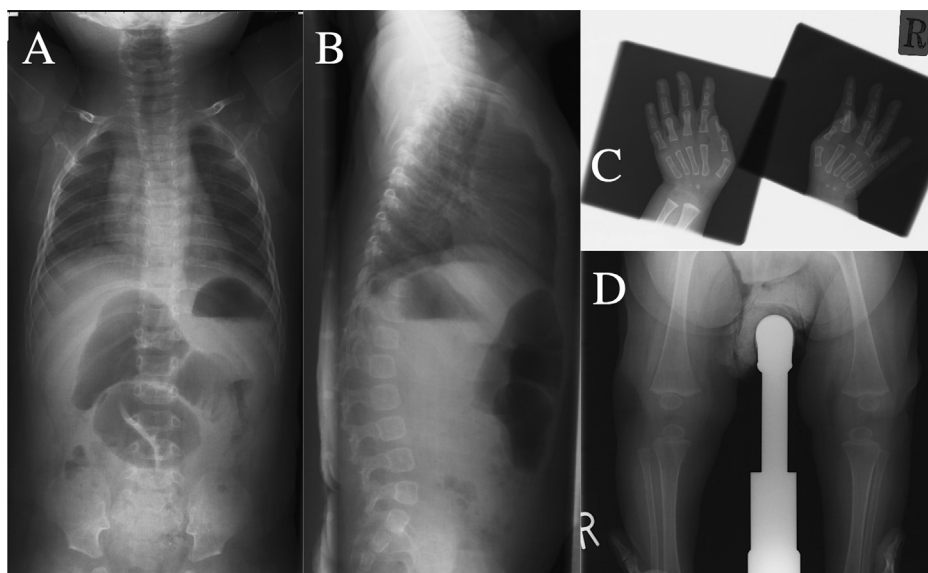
Radiographs at 5 months of age.
